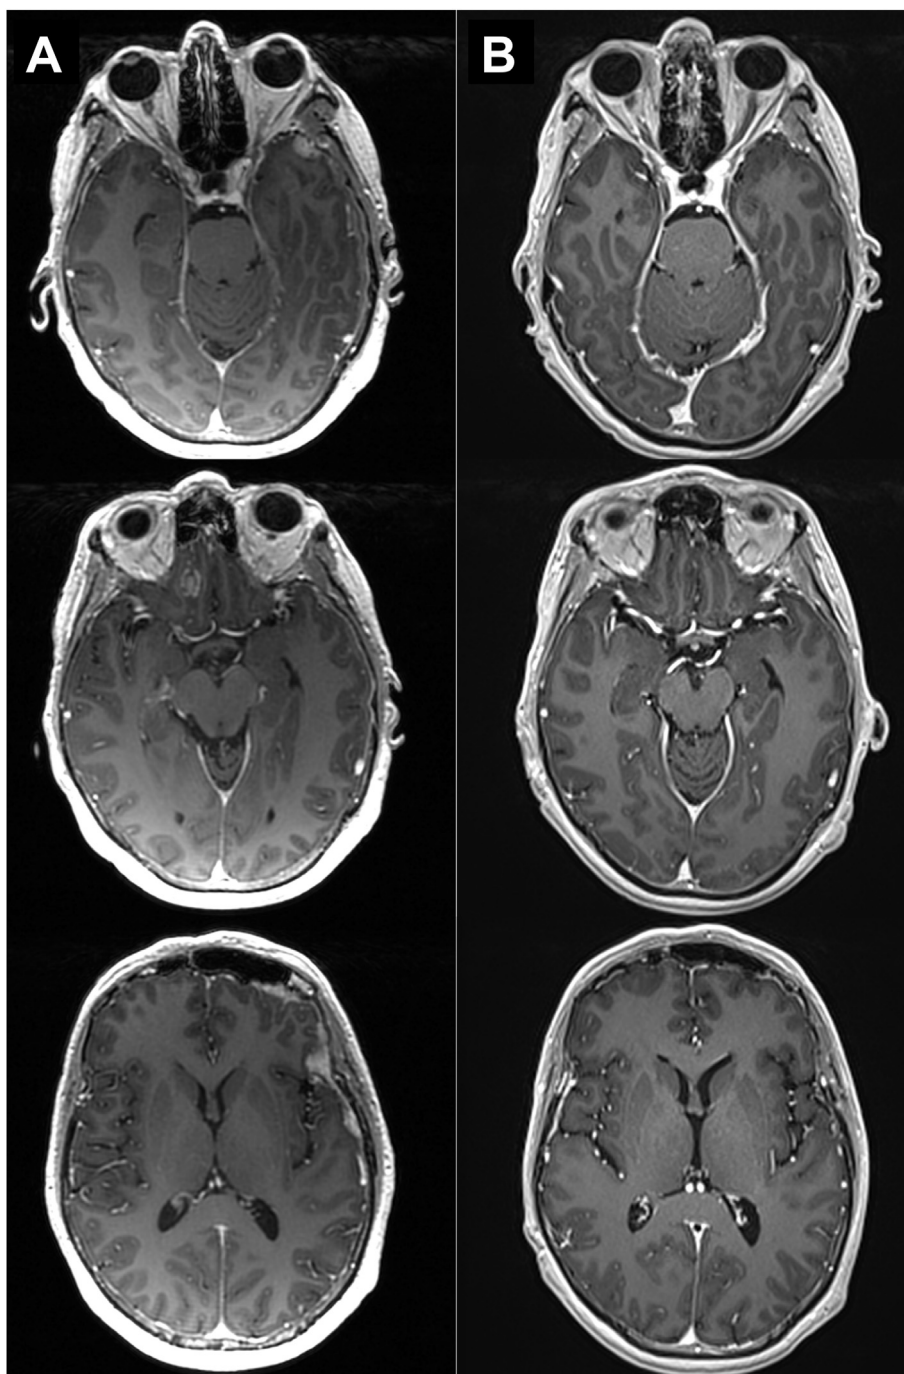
Diagnostic brain magnetic resonance imaging (MRI) showing the nodular lesions of leptomeningeal carcinomatosis secondary to hormone receptors positive, HER2 negative breast cancer compared to the brain MRI at 3 months after completion of radiotherapy.
